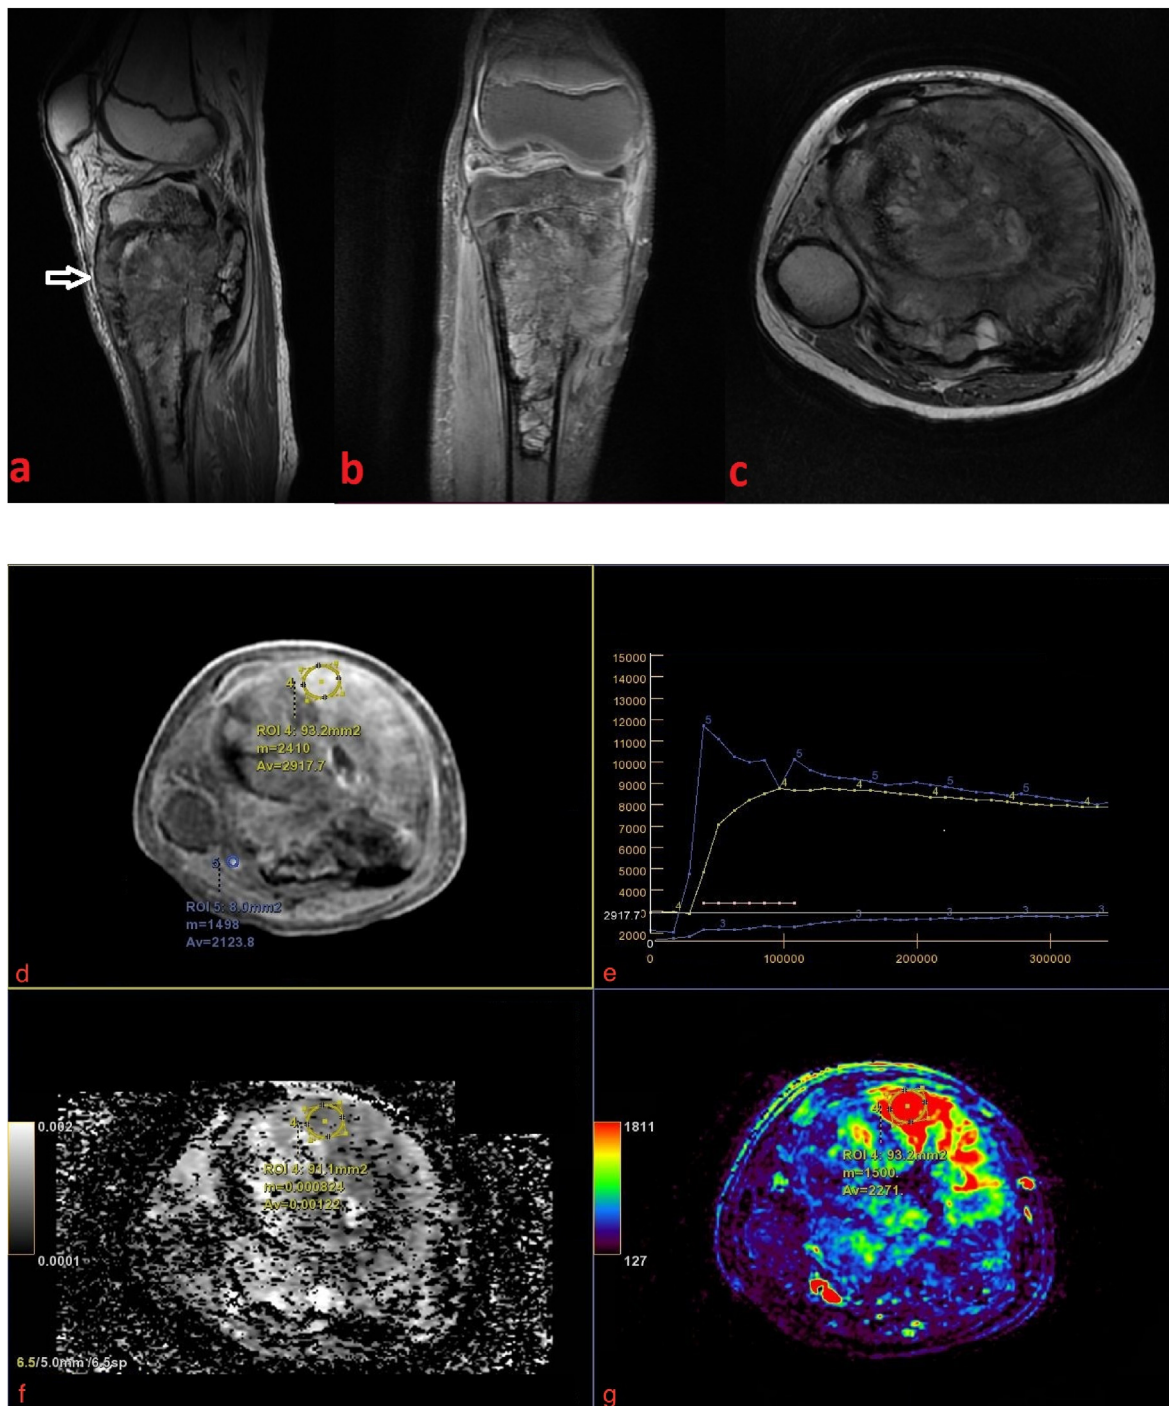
MRI imaging of a 12-year-old male patient. Sagittal T2 weighted (a), coronal PDFS (b) and axial T2 weighted images show an ill defined lesion involving the meta-diaphyseal region of tibia, crossing the growth plate to involve the epiphysis as well. Periosteal elevation is seen along anterior tibial cortex (white open arrow in a). Extension in surrounding tissue is seen.
